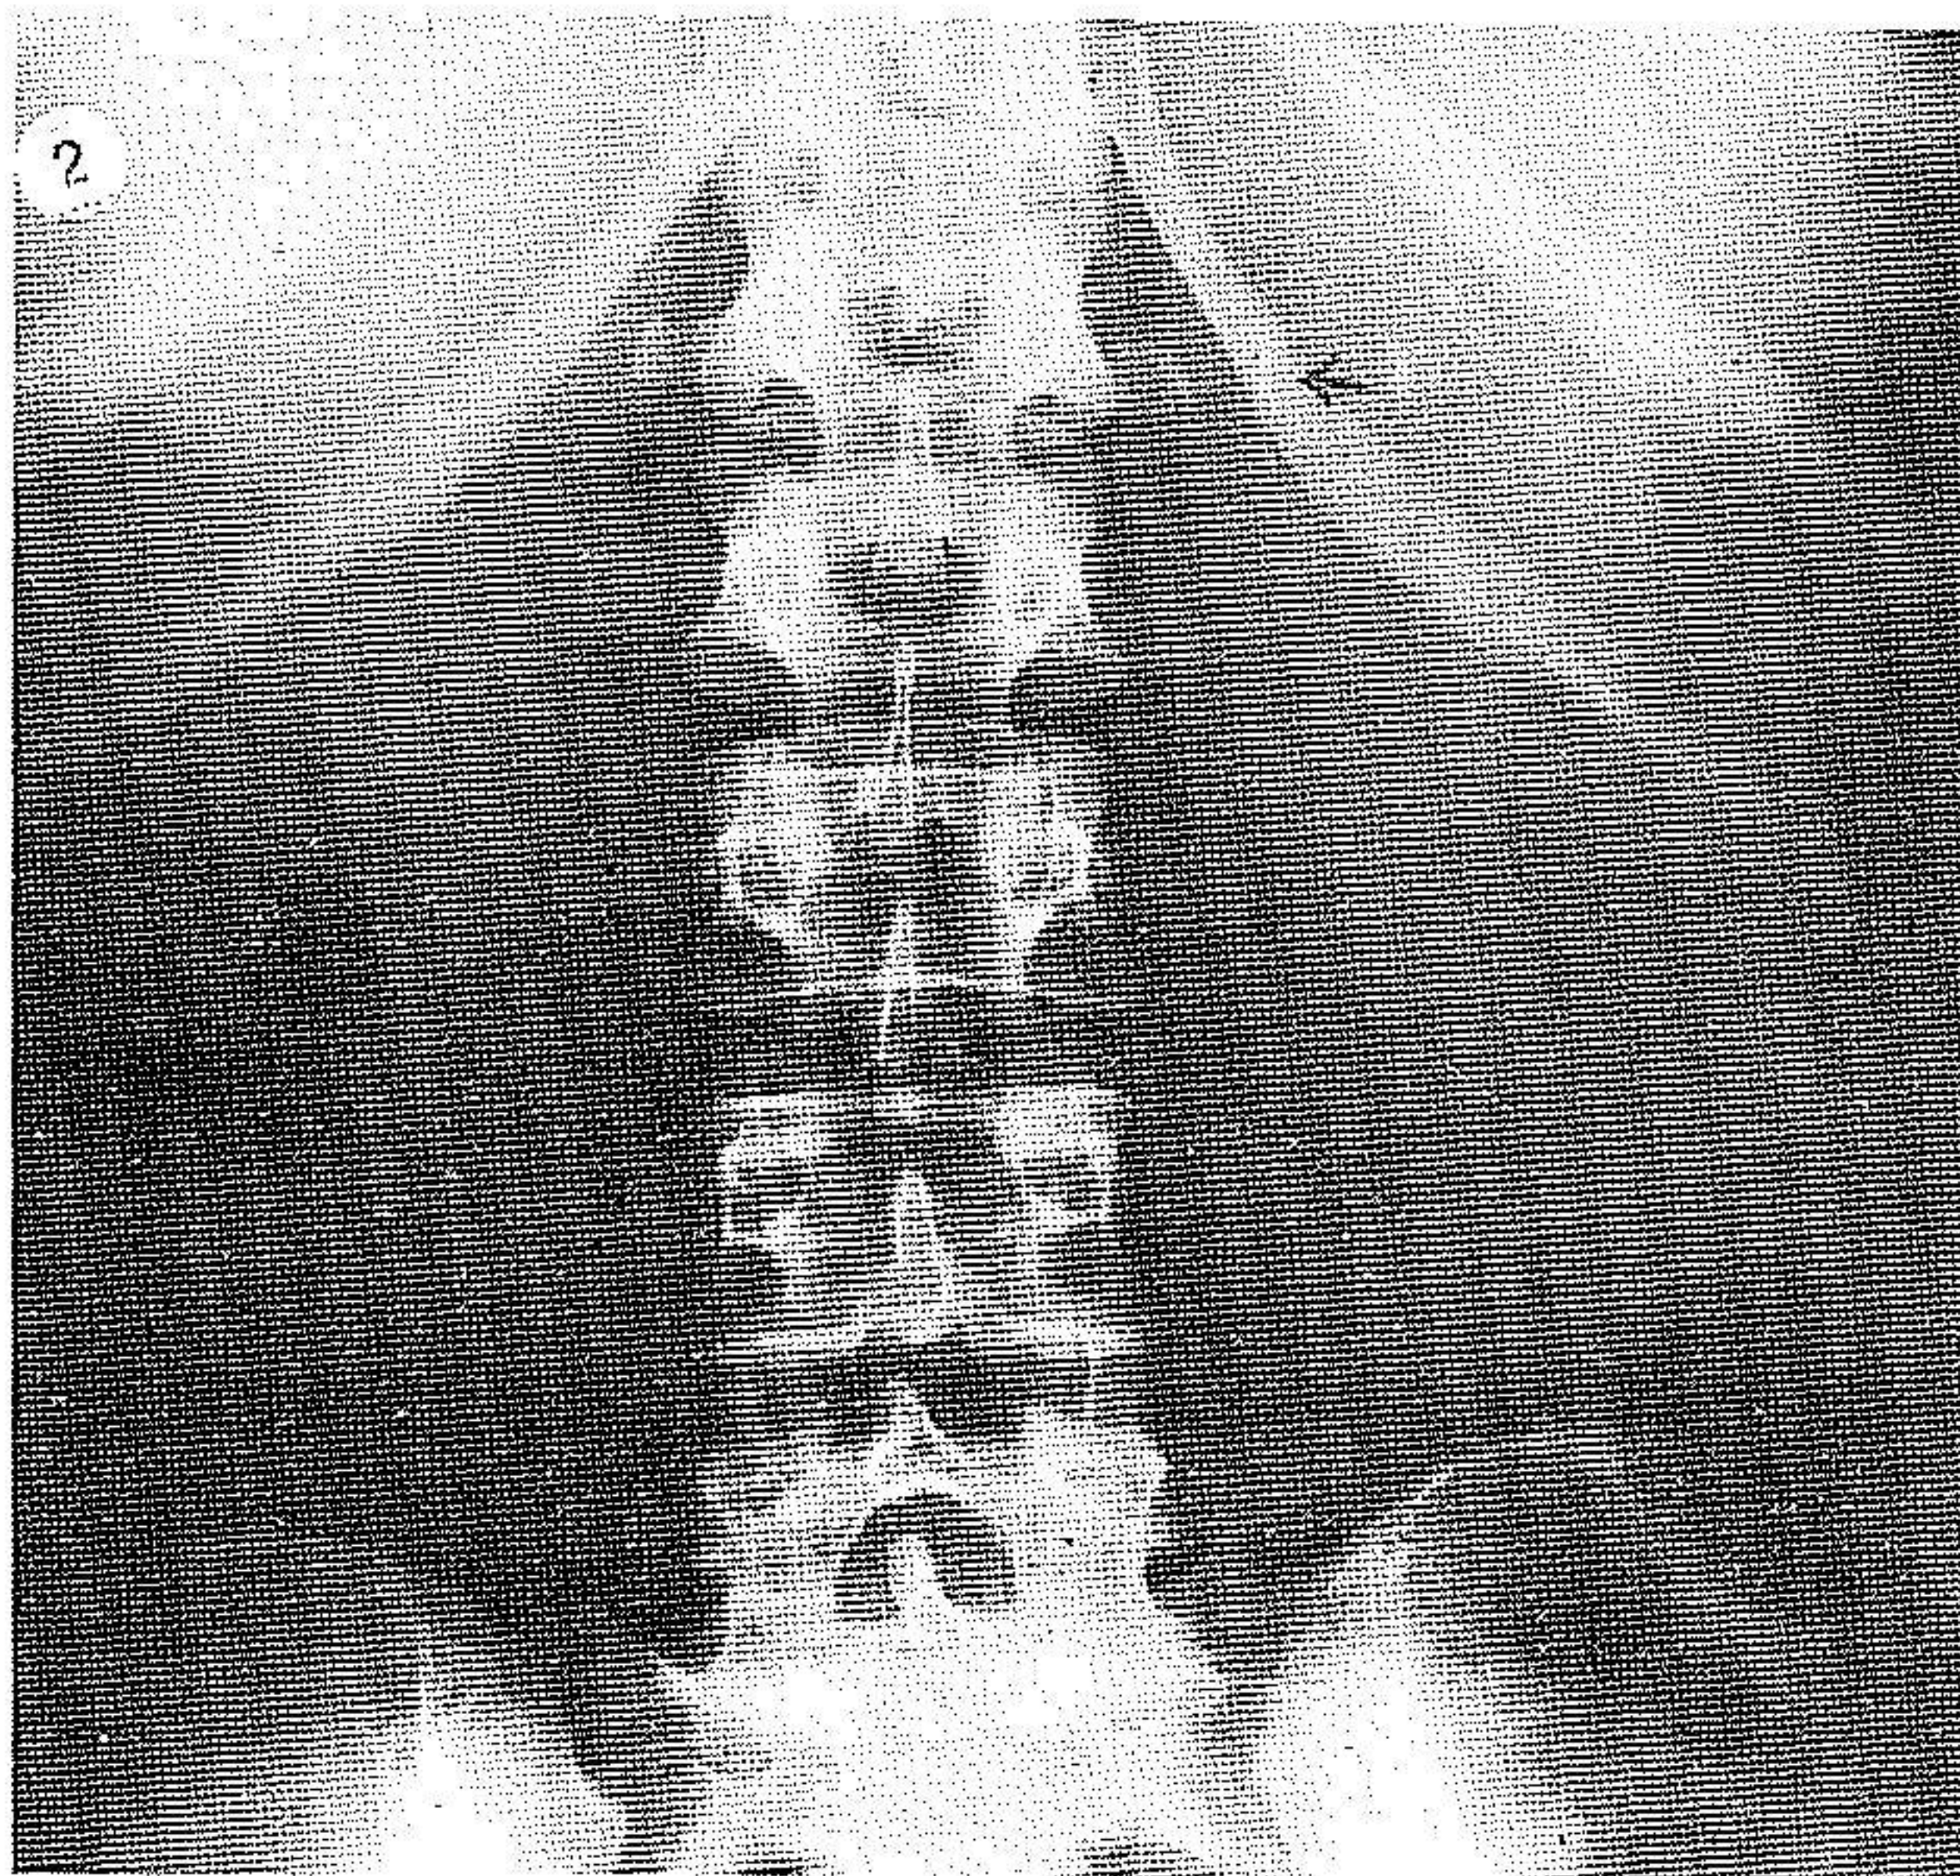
Curvilinear calcification on plain film due to a hydatid cyst of kidney. (Case 4).
